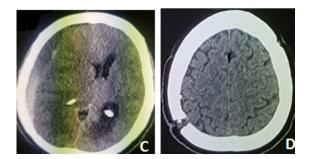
Axial slice brain CT scan showing DCSH in (A) left, and (C) right. In (B) and (C) control imaging performed one month after the surgical procedure showing the drill holes and not objectifying the presence of DCSH.
